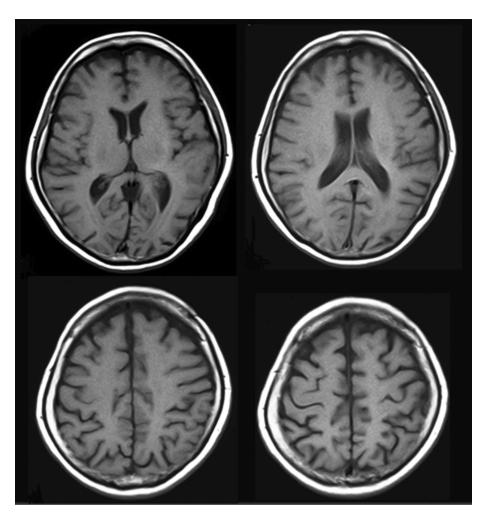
Magnetic resonance imaging $(T_1$ -weighted image) showing no atrophy or ischemic change.
